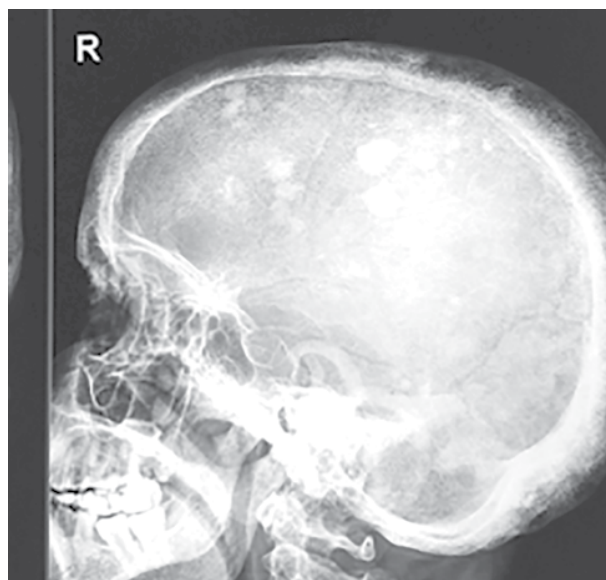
X-ray skull showing lytic and sclerotic lesions.
